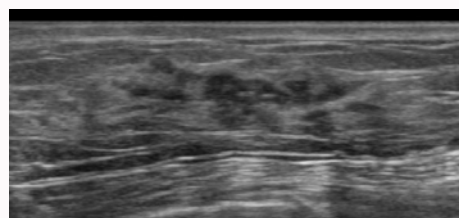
Ultrasonography (US) showing an irregular hypoechoic mass with an indistinct margin and calcification. A US-guided biopsy demonstrated ductal carcinoma.
